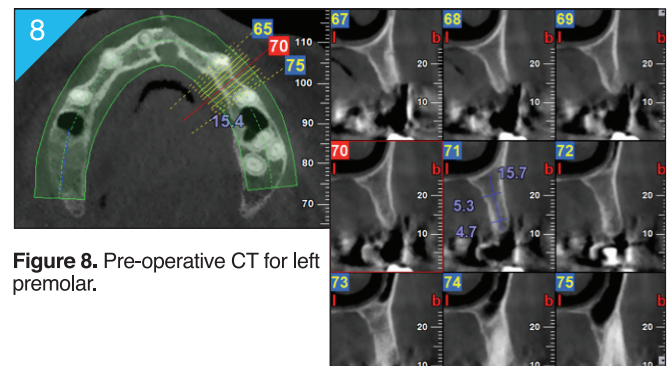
Pre-operative CT for left premolar.
